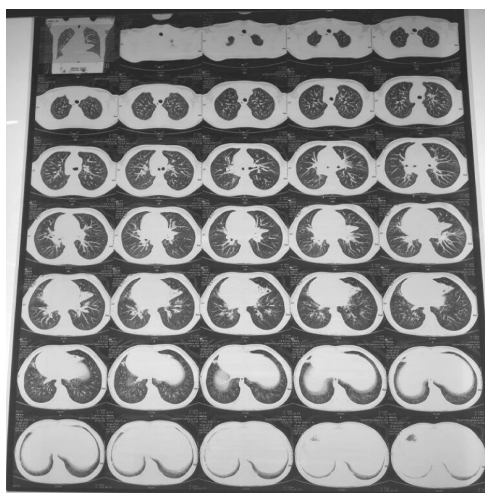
CT scan of chest revealed middle lobe collapse consolidation with bronchiectatic changes and pulmonary inflammatory lesion (Rt), dextrocardia and situs inversus.
